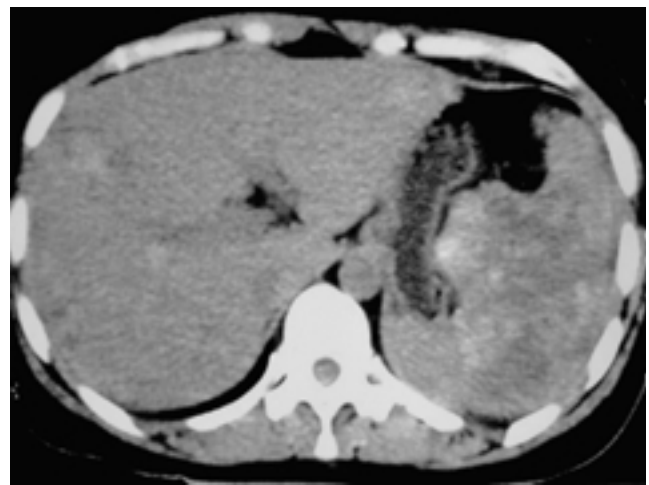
The contrast-enhanced CT shows multifocal ill-defined, heterogeneously enhanced masses in both lobes of the liver and the spleen.
